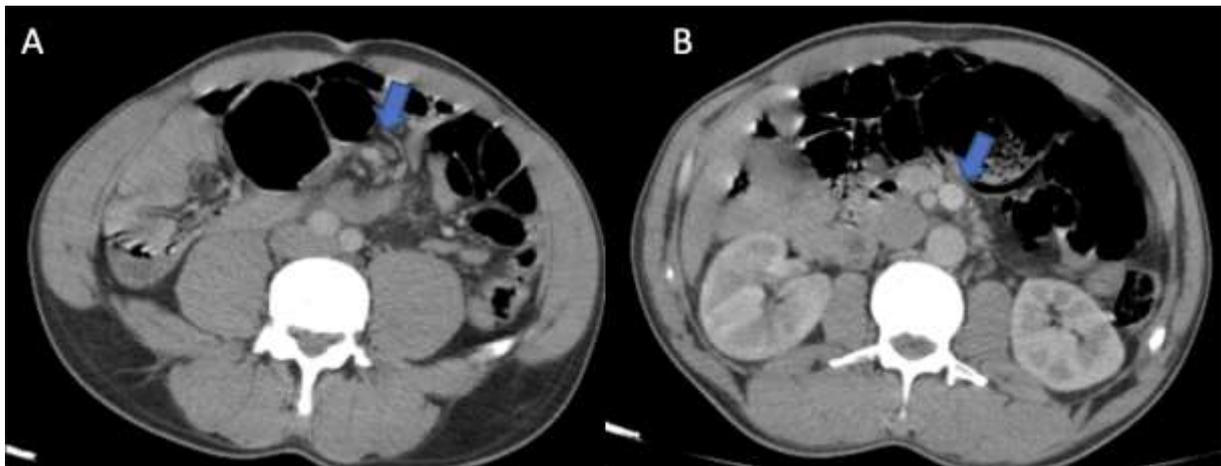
Axial CT scan at the portal phase of the second patient, highlighting the whirlpool sign (arrow in Figure A) and the misplacement of the mesenteric vessels (arrow in Figure B)
